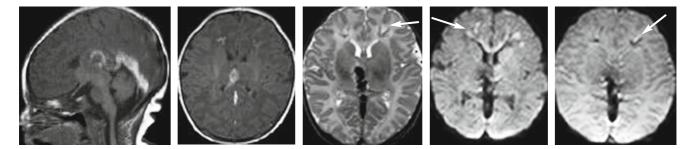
A term baby with an evident and diffuse venous thrombosis, showing thrombi and mild involvement of frontal medullary veins (*arrows*). *Left to right*: MR sagittal T1, axial T1, axial T2, DWI and paramagnetic. (Courtesy of S. Martinelli)
